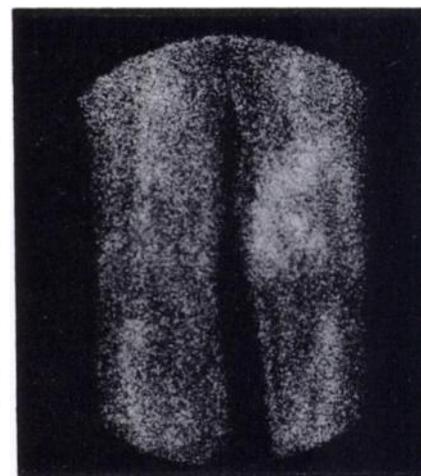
False-positive ^{99m}Tc-AGAB scan. This patient with Hemophilia A (since 1964) and HIV positive (since 1989) presented with complaints of the left knee joint. X-ray and laboratory investigations showed normal findings. Left knee joint puncture revealed an aseptic, reactive synovitis following hemarthrosis.
